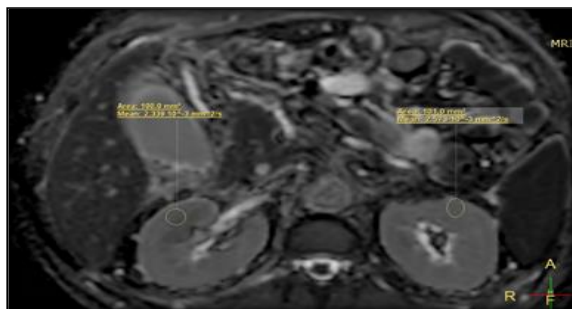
MRI DWI image showing ADC values
